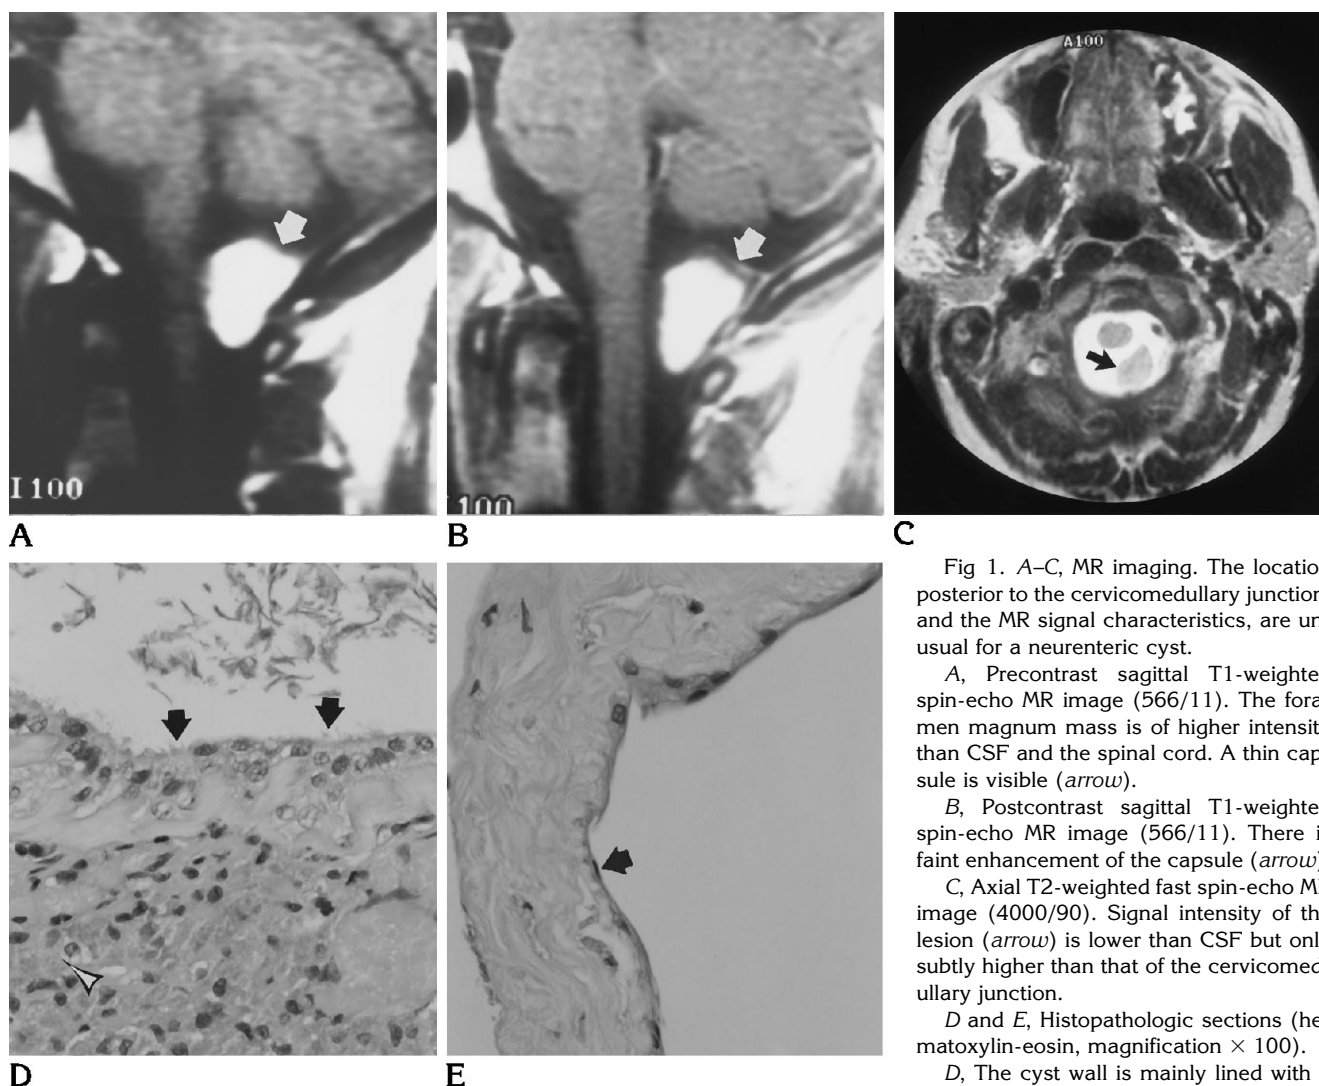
A–C, MR imaging. The location posterior to the cervicomedullary junction, and the MR signal characteristics, are unusual for a neurenteric cyst.
